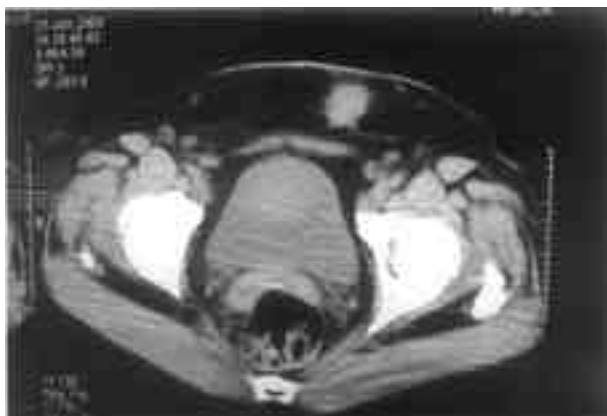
Lower cuts pelvic CT- scan with contrast showing an ill defined lesion with surrounding tissue reaction, appearing extra pelvic and predominantly situated in the subcutaneous tissue
